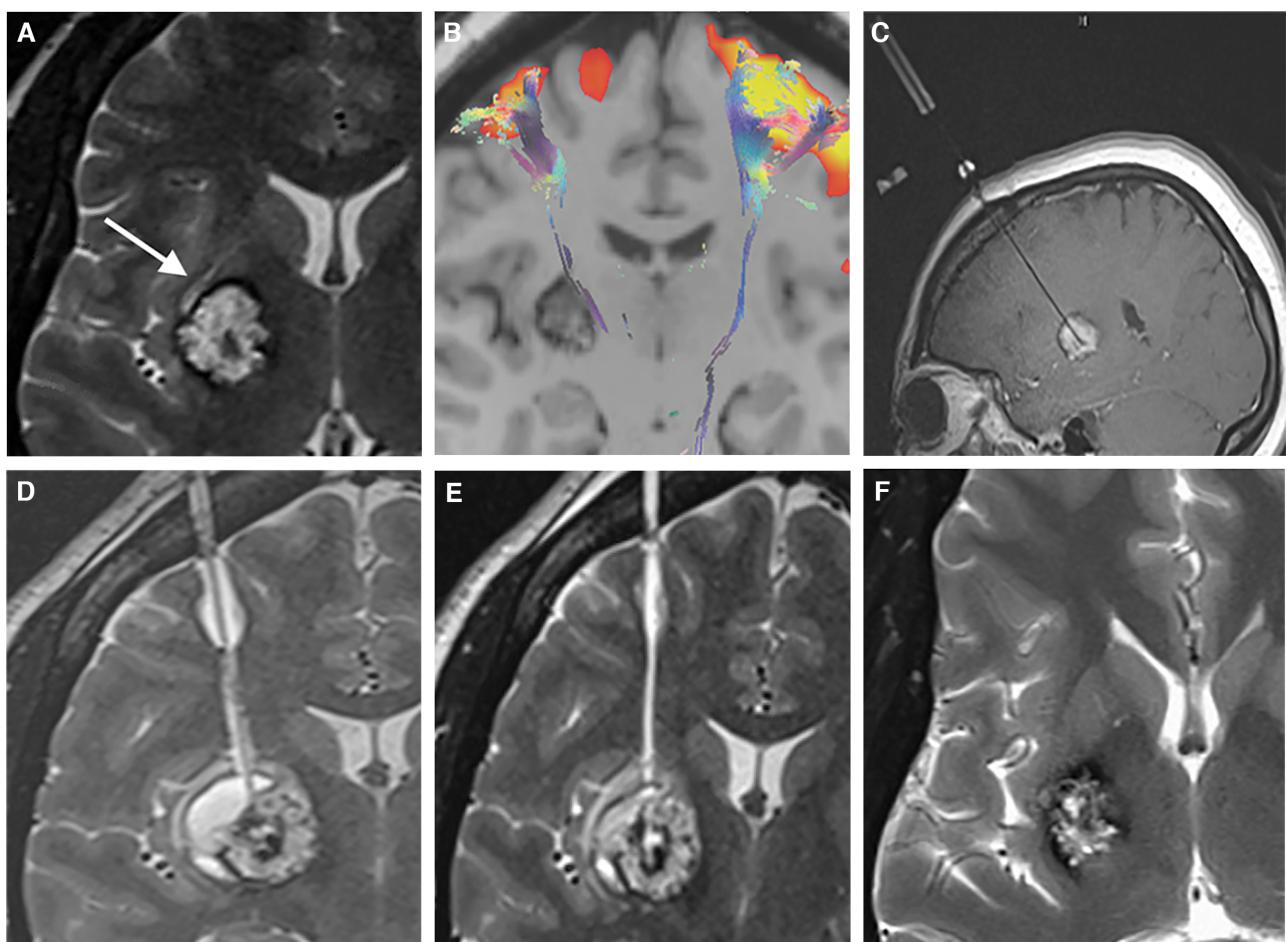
Ablation of CCM of right putamen in patient 2. A, Preoperative axial T2-weighted image showing the mixed-intensity lesion prior to ablation with arrow indicating location of developmental venous anomaly (DVA). B, Coronal T1-weighted image with processed motor tractography showing lesion mass effect upon fibers of the internal capsule. C, Intraoperative sagittal T1-weighted image showing cannula placement into the lesion. D, Intraoperative paracoronal T2-weighted image showing interval collection of fluid with same intensity as cerebrospinal fluid (saline) overlying the lesion and tracking up the cannula. Central hypointensity in the lesion itself reflects early post-LITT changes. Device inspection confirmed malfunction with saline leak. E, After cannula removal, the fluid decompressed along the tract and deeper within the lesion. F, Follow-up at 6 mo axial T2-weighted image showing partial involution of the lesion.
